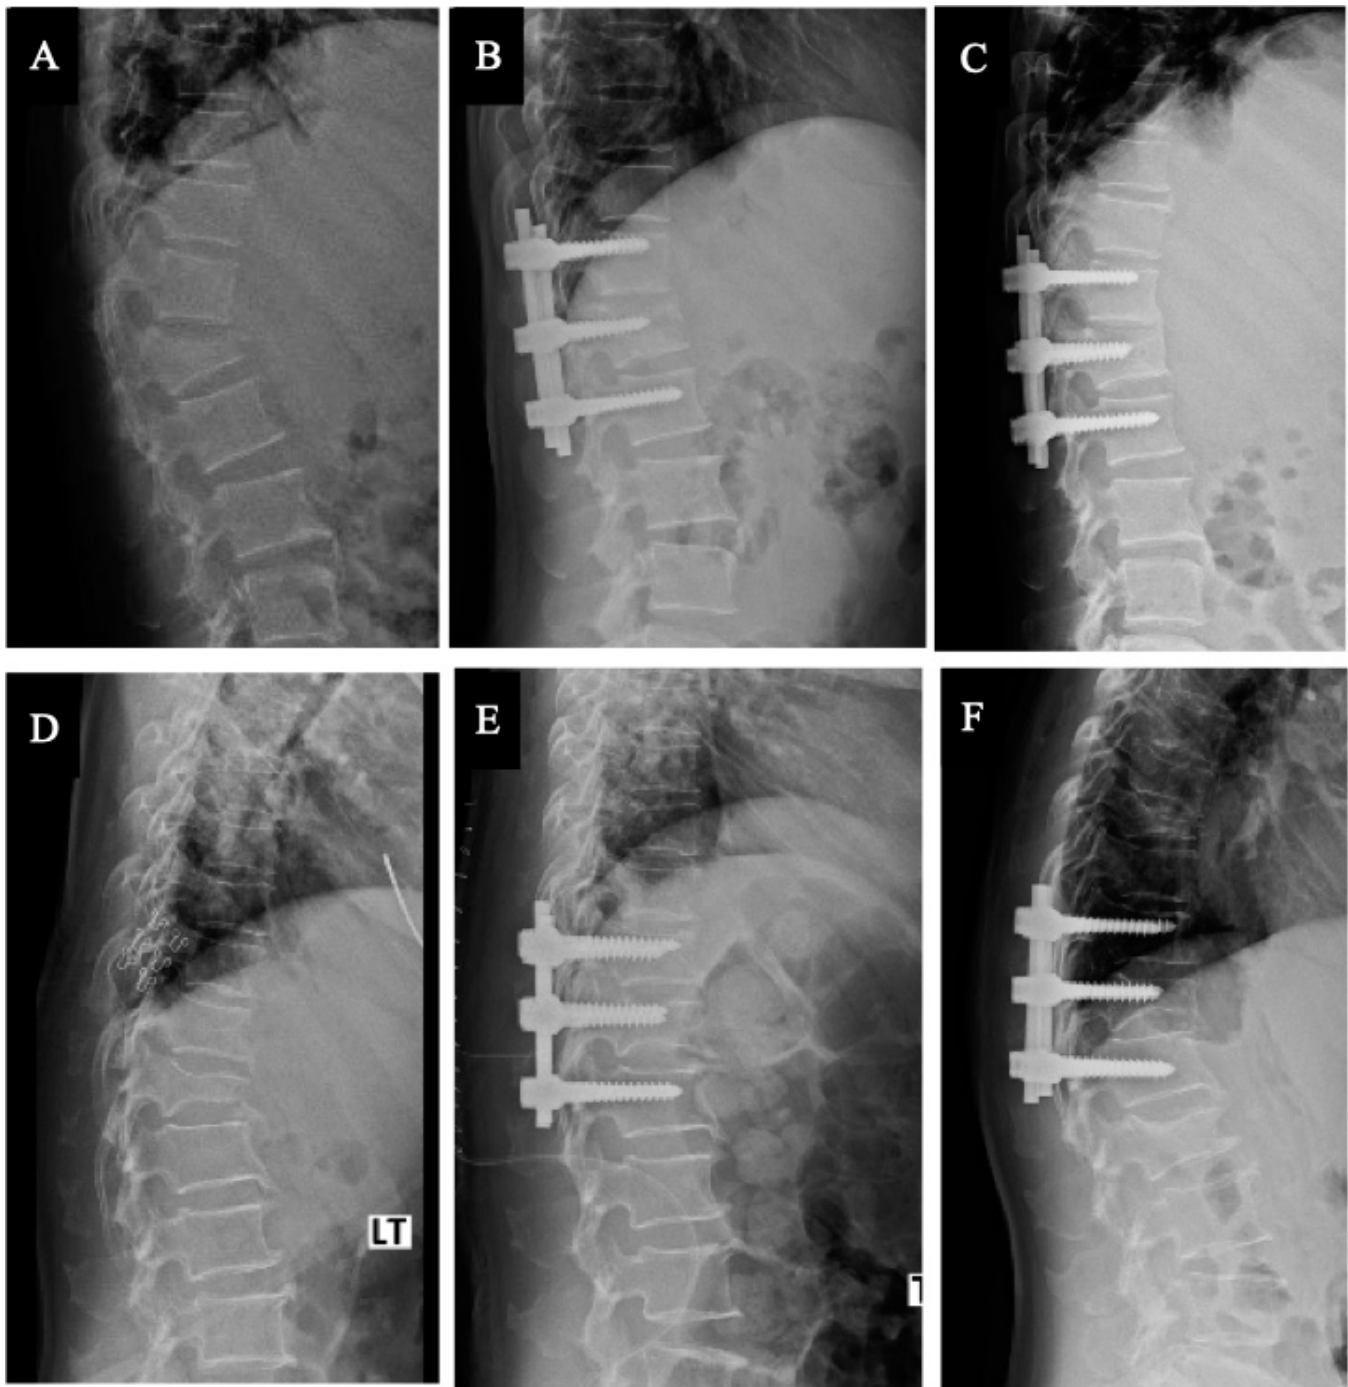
Radiographs of patients who are stable (A, B, and C) and kyphosis progression (D, E, and F) after short-segment pedicle fixations. (A) and (D) were obtained immediately after injuries. (B) and (E) were obtained after fixation. (C) and (F) were obtained at a 2-y follow-up.
